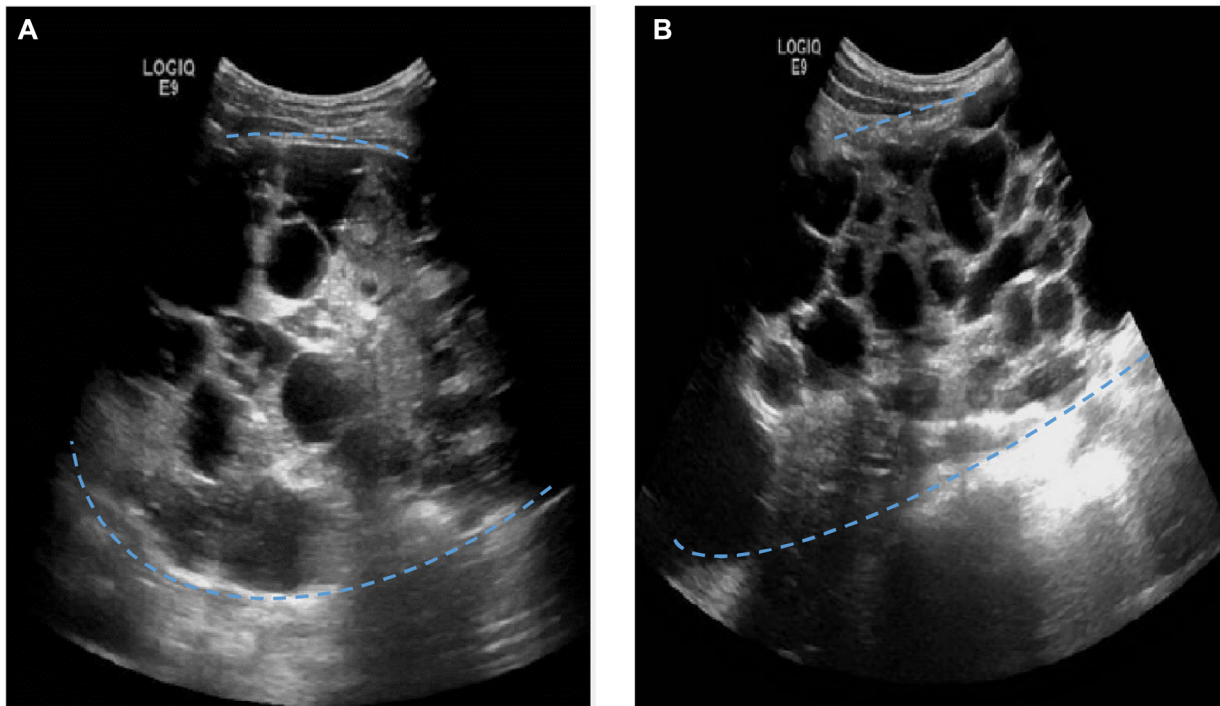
Ultrasound of kidneys. A: Coronal view of left kidney. B: Sagittal view of right kidney.
